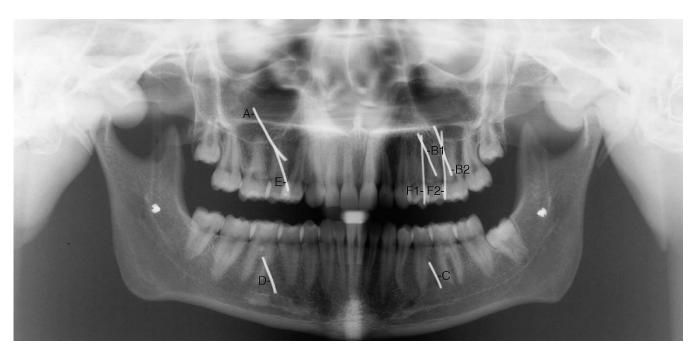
The panoramic radiograph of the dry skull with brass wire markers in place. It was taken with the Gendex Orth Oralix FD 5 Ceph unit.
